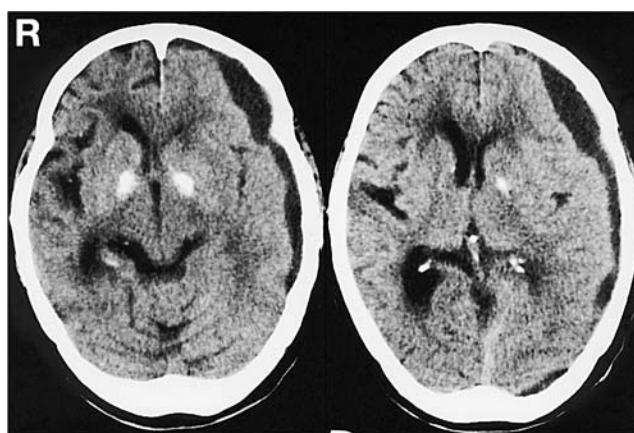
Computed tomography scans taken 7 days after admission showing excellent decrease of the shift of the midline structures. The hematoma appeared as a low-density area.
